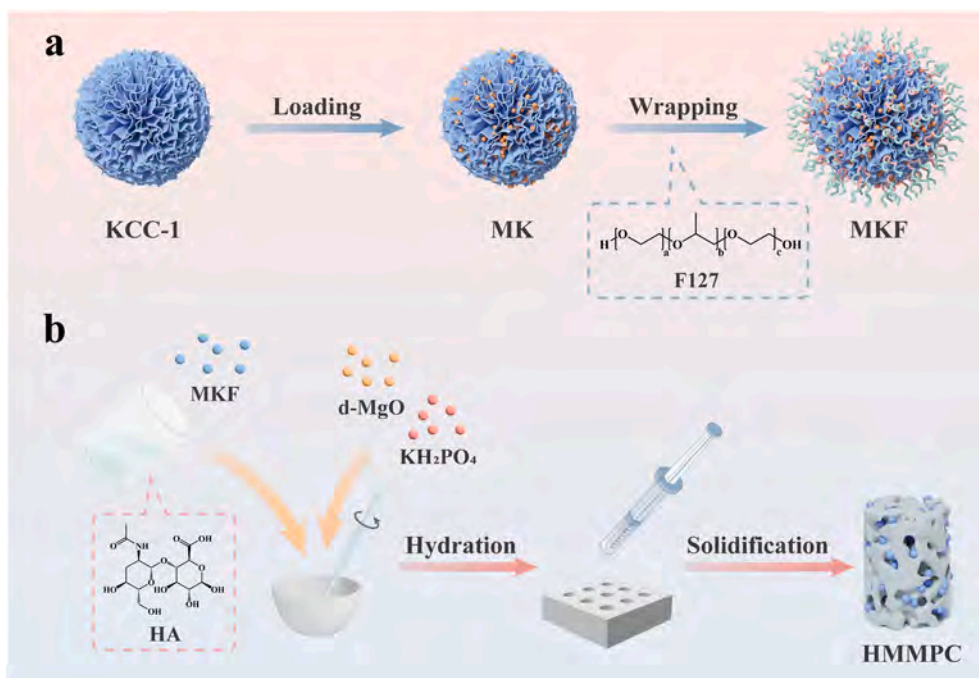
(a) Synthesis of the drug-loaded ultrasound-responsive nanocapsules. (b) Preparation of modified MPC.
